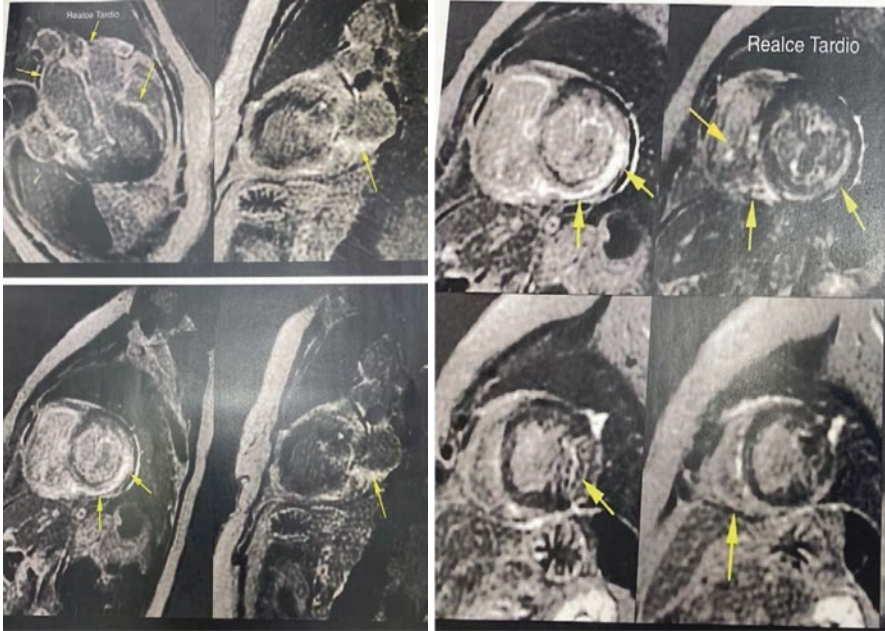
MRI of the resting heart with diffuse late enhancement of the atrial and right ventricular walls, as well as heterogeneous late enhancement of the nonischemic left ventricular myocardium. There is an increase in the native T1 of the myocardium (approximately 1200 ms) and in the ECV (46%, considering a recent hematocrit of 37%) in the medial inferoseptal segment, which also suggests amyloidosis
